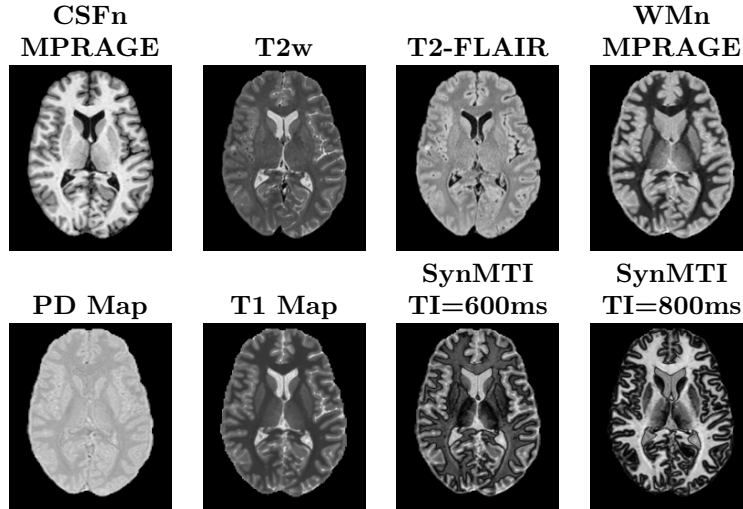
A slice of the preprocessed data and synthetic MTI images. The first row shows the contrast-weighted images directly measured from the subject, after preprocessing: The first three are inputs to the model, while the rightmost one is the desired output. The second row shows two quantitative parameter maps calculated from the two MPRAGE images (as described in Sec. 2.2) and two synthetic MTI (SynMTI) images generated using the procedure described in Sec. 2.3. All MR images shown in this paper correspond to the same slice of the same subject.
